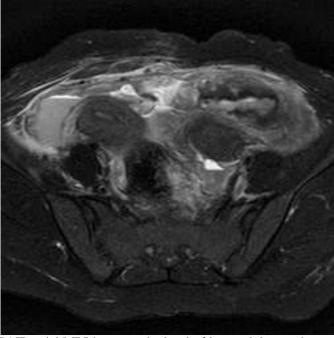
T2 weighted SPAIR axial MRI image at the level of lower abdomen demonstrates normal cornu of uterus on right side and heterogeneous placenta with internal haemorrhage appearing dark with hyper intense areas within on left side, attached to the ruptured left horn and sigmoid mesentery. Peritoneal collection also noted.
